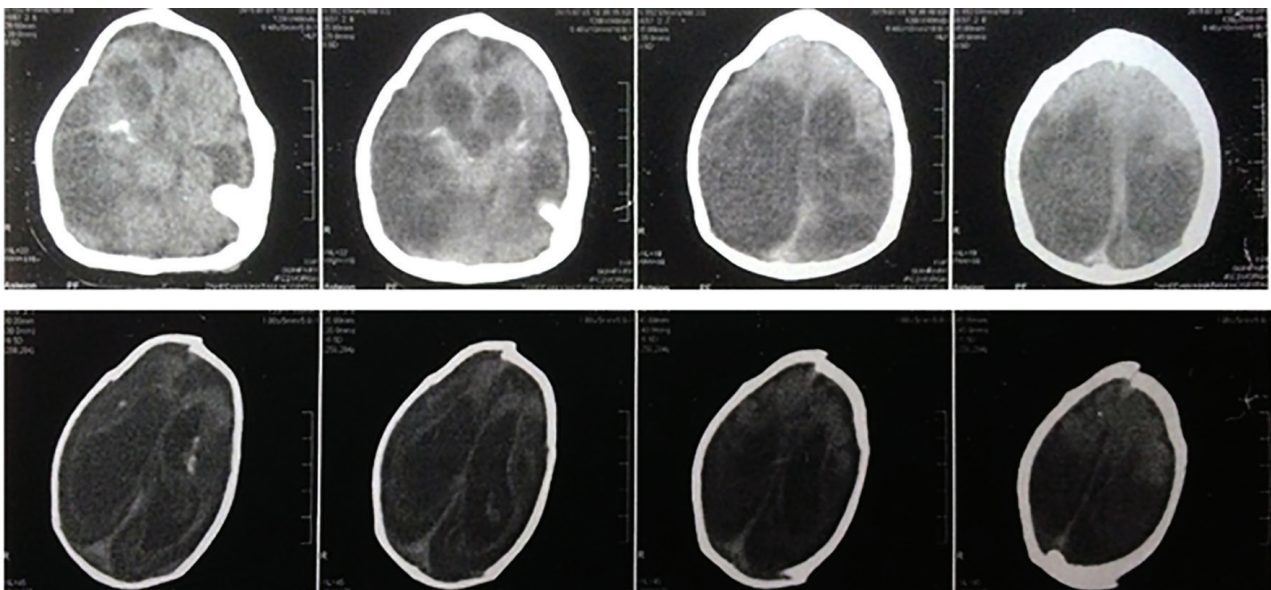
Axial brain CT-scan of the fetus demonstrated multiple skull fracture, interhemispheric SDH, intraparenchymal contusions and hemorrhage, intraventricular hemorrhage and loss of white-gray differentiation.
